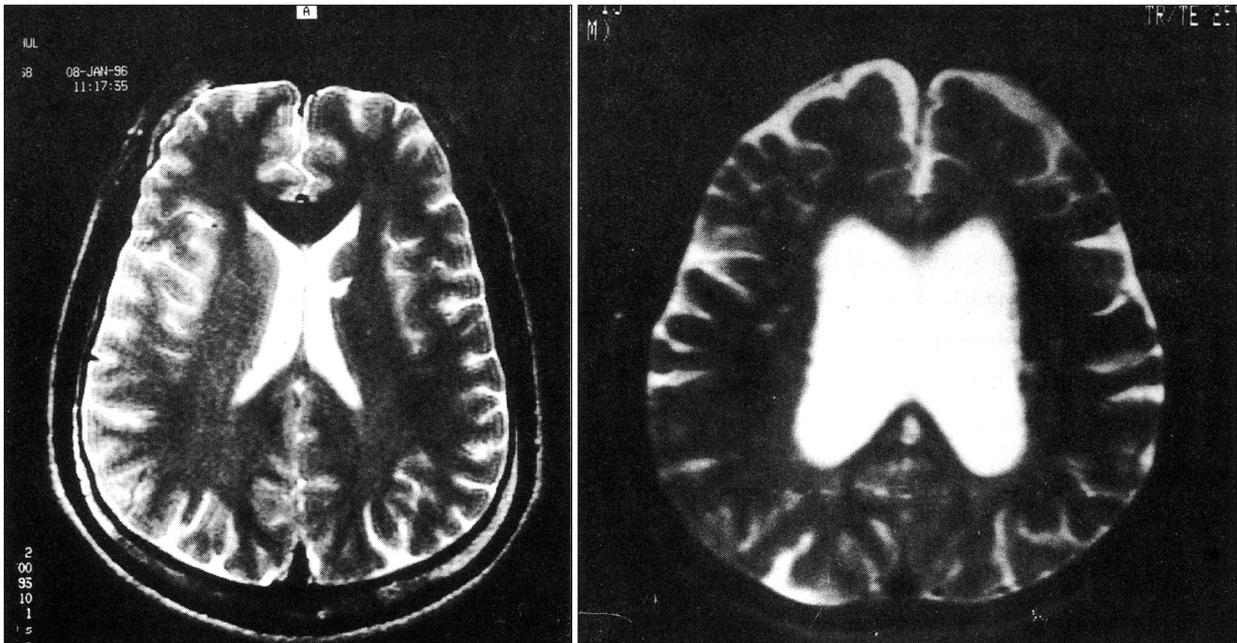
T2-weighted MR images demonstrates left single periventricular hyperintensity(left) and multiple periventricular and deep white matter hyperintensities(right).
